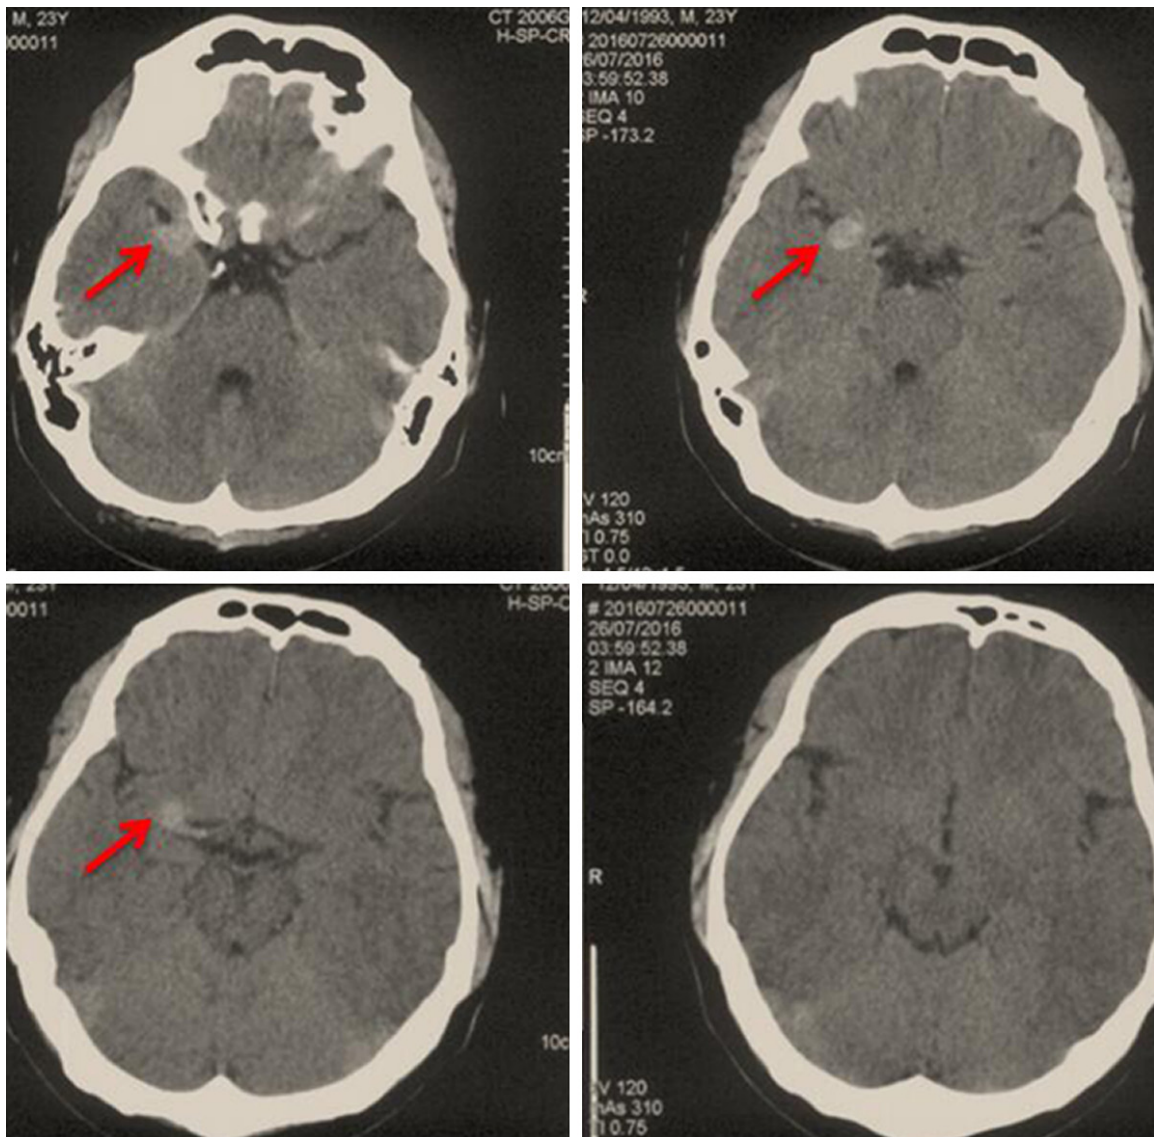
Preoperative CT scan of the head. The hyperdense round-shaped lesion in the lateral fissure was not complicated with a subarachnoid hemorrhage. The red arrow indicates a round lesion in the right sylvian fissure.
